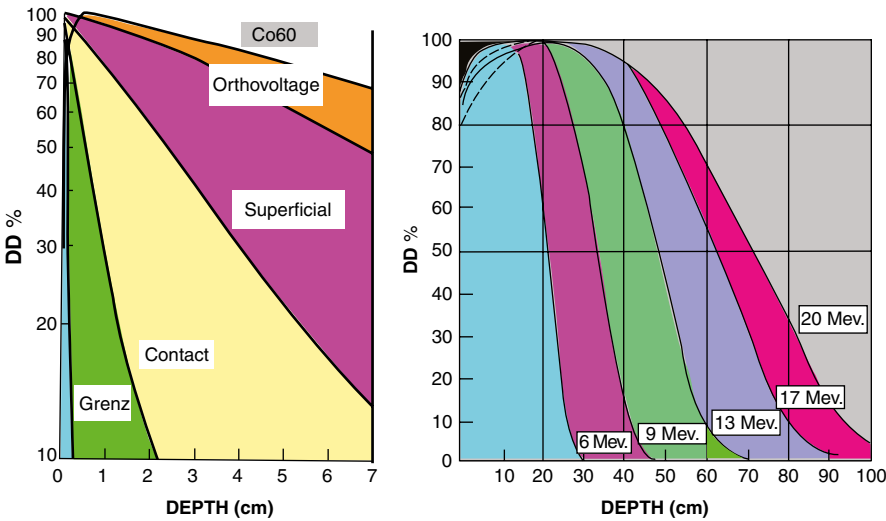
PDDs for various X-ray and electron energies
